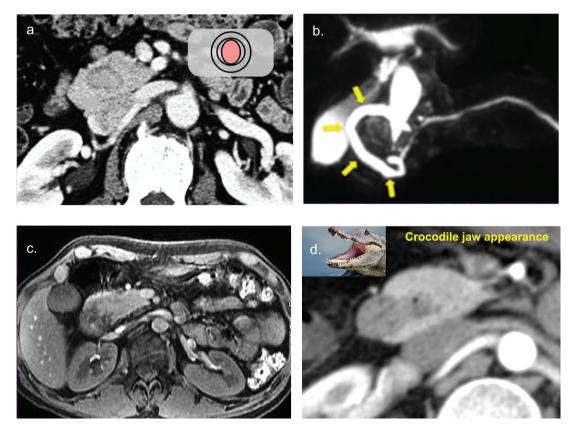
(a.) CECT. Complete type of annular pancreas. The pancreatic tissue encircles the duodenum. *(b.)* MRCP. Extramural type of annular pancreas. The yellow arrows indicate the annular duct in the extramural passing posteriorly and wrapping around the descending duodenum. *(c, d.)* MRI & CECT respectively. The "crocodile jaw appearance" is produced by an incomplete encasement of the duodenum by pancreatic tissue.
